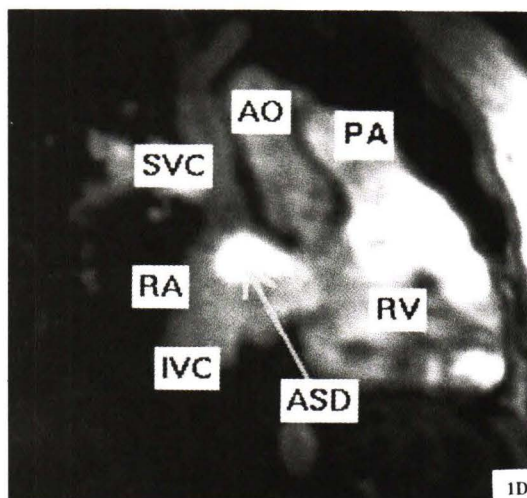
Cardiac MRI of an ASD (enface view of the ASD).
